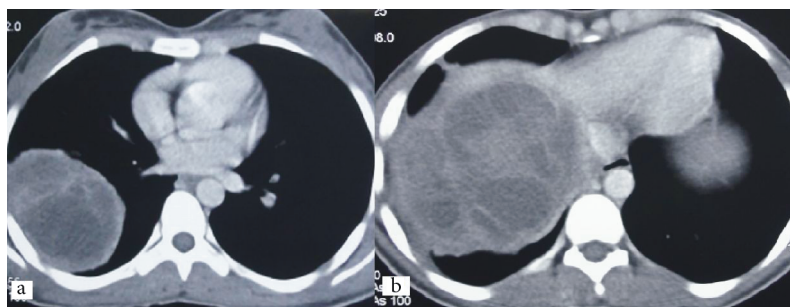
The appearance of cysts in the (a) right lower lobe and (b) liver on thorax computed tomography.
